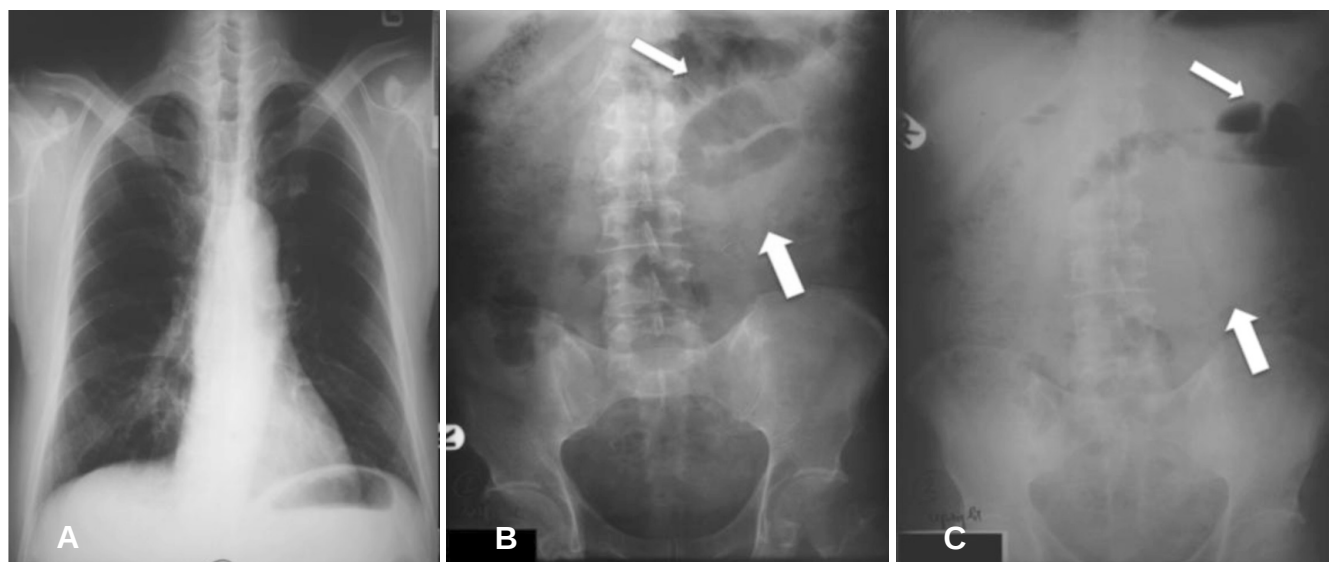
Acute abdomen radiographs
